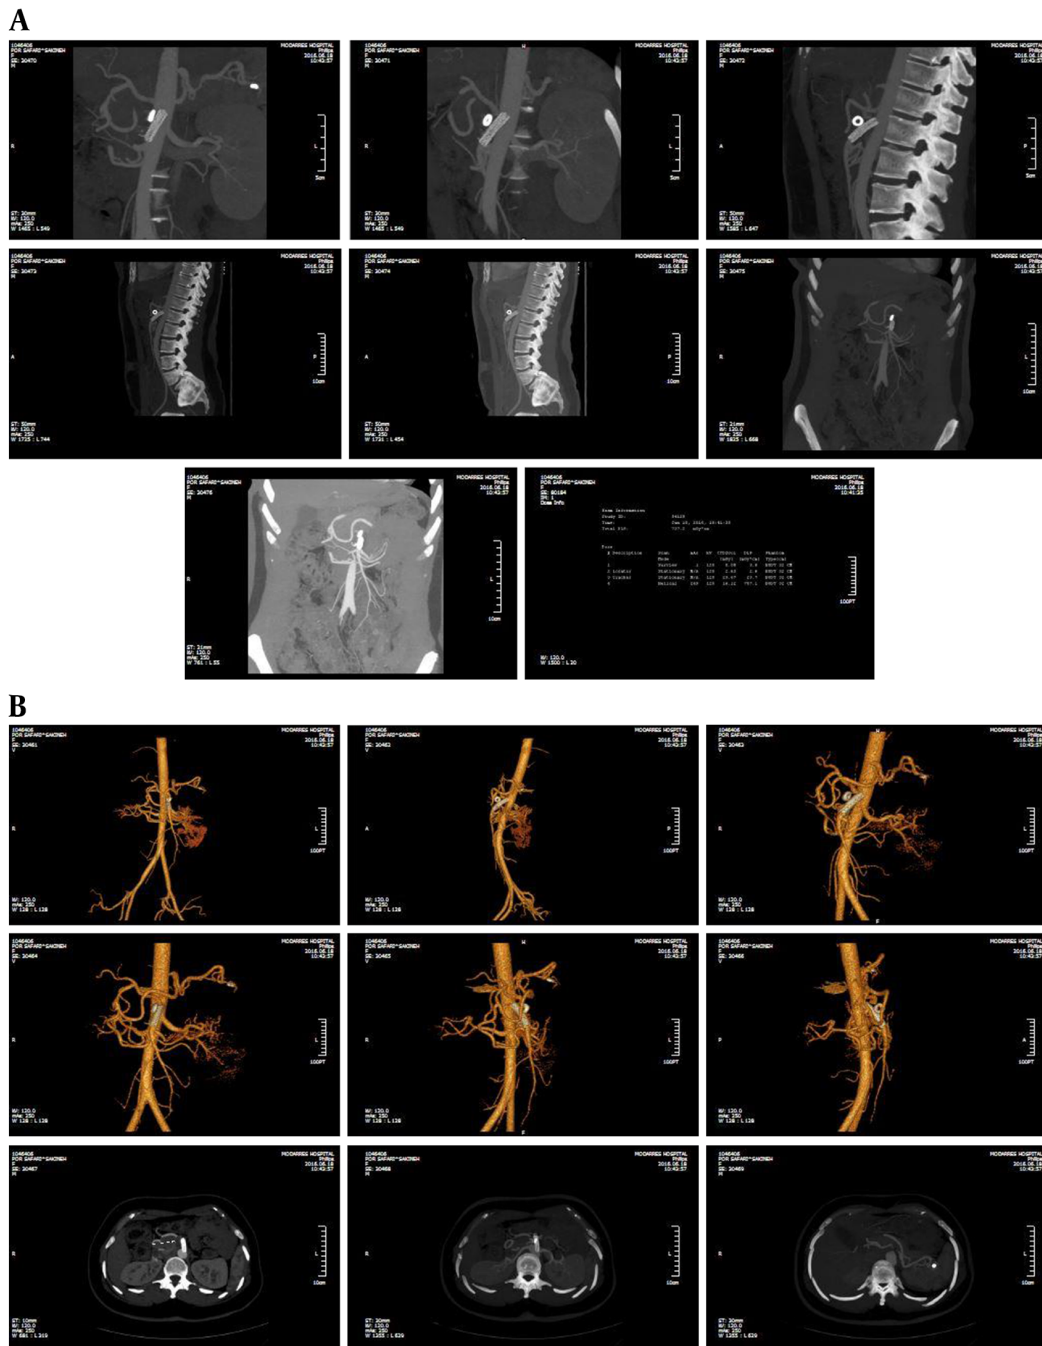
Imaging (A, B) After the Endovascular Repair Using CT Angiography
